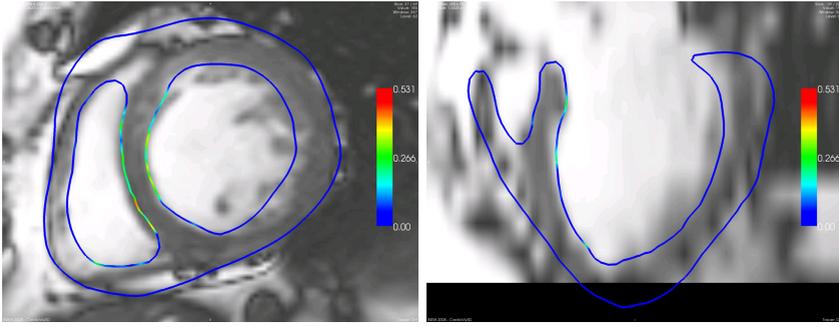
Results of the motion tracking: delineation of the estimated mesh superimposed with Cine-MRI at end-systole in short- and long-axis views. Colour encodes the intensity of the image forces (blue: small, red: large).
